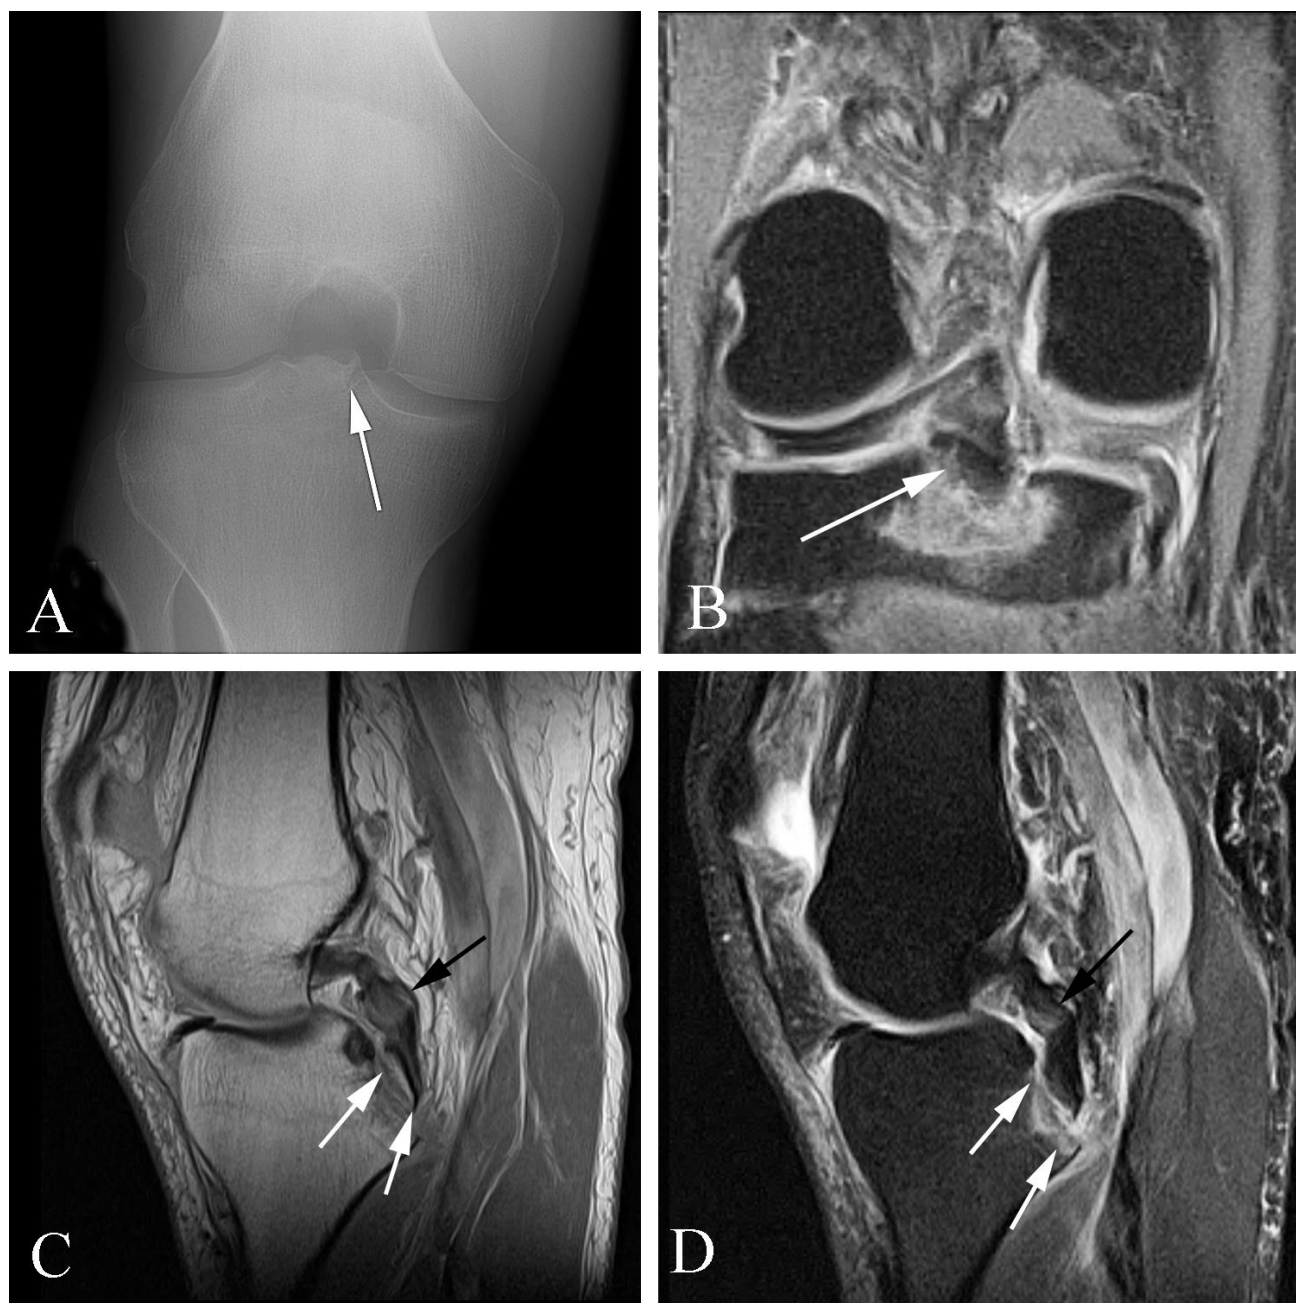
Fracture with associated soft tissue injury (posterior cruciate ligament avulsion) in a 49 year old man with pain following trauma. A. AP “notch” view of the knee shows a relatively subtle lucency in the mid portion of the tibial plateau. B. Coronal fat-suppressed proton density MR image shows a bone fragment of the tibial plateau (arrow) surrounded by a wide band of abnormal signal intensity. C. Sagittal proton density MR image shows separation of the posterior cruciate ligament from its insertion along the proximal, posterior tibia (white arrows). Note the abnormal thickening of the mid-portion of the posterior cruciate ligament compatible with tear (black arrow) D. Sagittal fat-suppressed T2 weighted image demonstrates abnormal signal intensity along the insertion of the posterior cruciate ligament (arrows).
